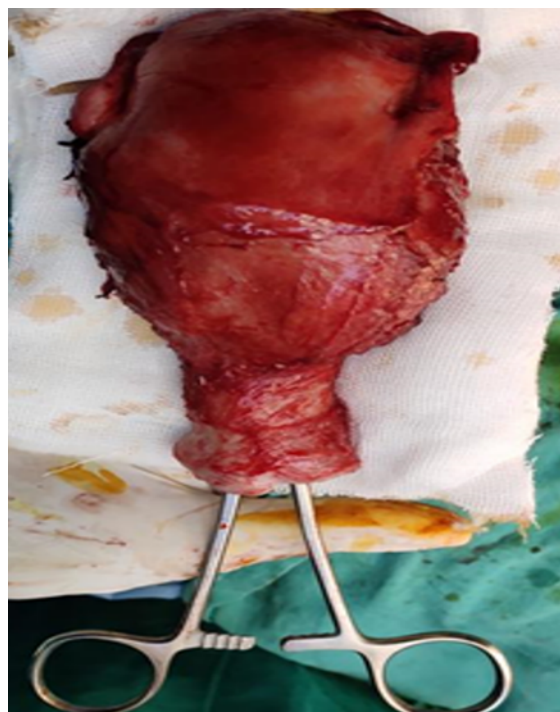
a): MRI pelvis -Uterine Mmass invading myometrium; b): Vascular uterus
